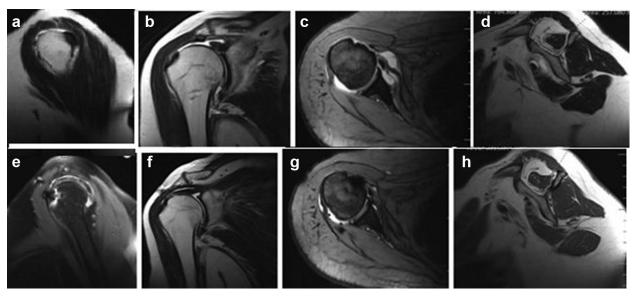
A 62-year-old female patient with an atraumatic chronic rotator cuff tear. (a, b, c) A large-sized supraspinatus and subscapularis tear was noted on the preoperative sagittal, coronal, and axial magnetic resonance imaging (MRI) scan. (d) Preoperative Goutallier grade 2 fatty infiltration and occupancy ratio of 0.37 in sagittal Y view. (e, f, g) Final follow-up shows type 1 repair integrity as per Sugaya classification. (h) The occupancy ratio diminished from 0.37 preoperatively to 0.33 at the 12-month follow-up; fatty infiltration increased.
